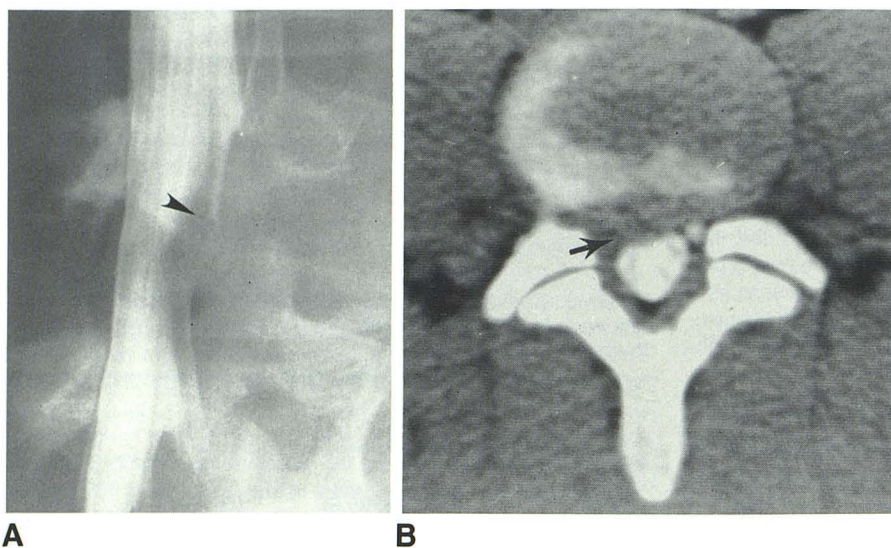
29-year-old man with probable L4–L5 disk herniation. Definite evidence of nerve-root compression. A, Oblique myelogram. Marked flattening and edema of right L5 nerve root (arrowhead) and amputation of its associated root sheath. B, CT scan. Lack of opacification of right L5 root sheath due to compression by disk material (arrow). Clinical response: asymptomatic at 6 month follow-up.
